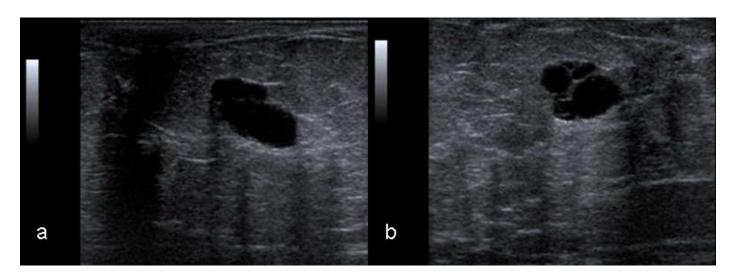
58-year-old man with benign simple breast cyst: Left breast ultrasound (using 12 MHz linear transducer) images in transverse (a) and longitudinal (b) axis demonstrate an anechoic cystic lesion with thin internal septations (<0.5 mm) and posterior acoustic enhancement. The surrounding breast tissue was consistent with subcutaneous fat, and no sonographic evidence of fibroglandular tissue was noted.
